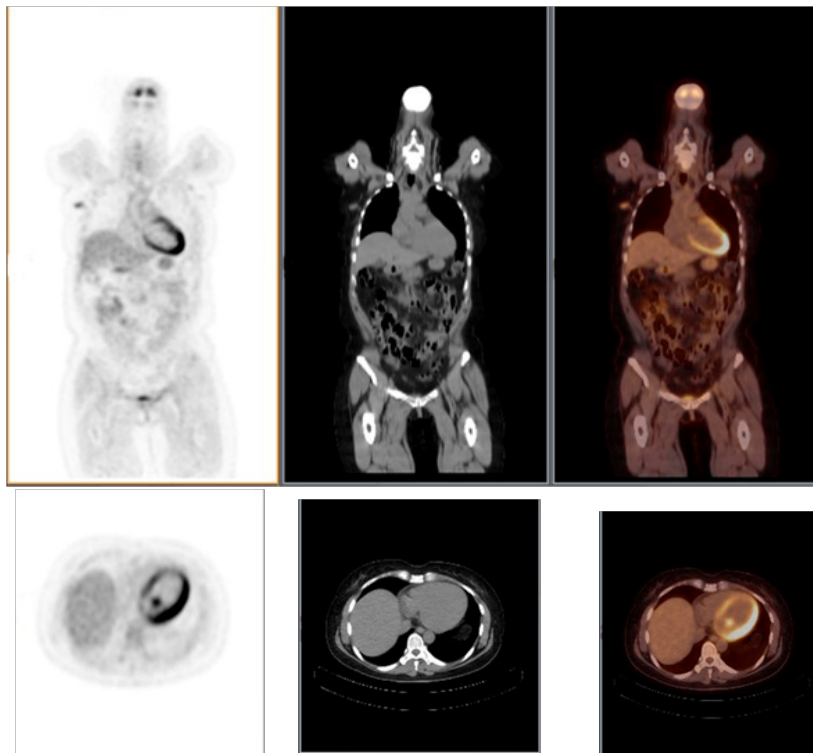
Coronal and axial images of PET, CT and fusion PET/CT, showing a heterogeneously diffuse increased uptake of fluorodeoxyglucose in the left ventricular wall and papillary musculature
